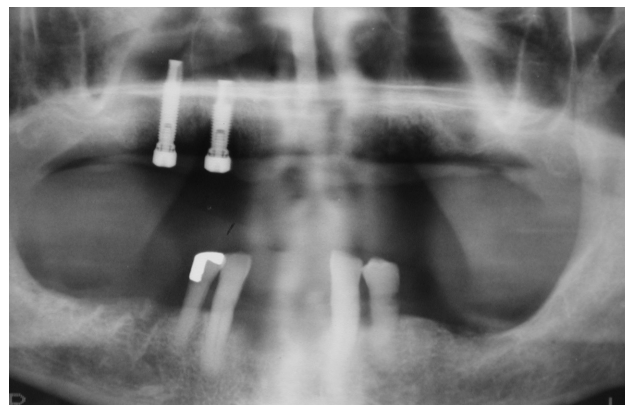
Radiograph of failure case after removal of four implants.
